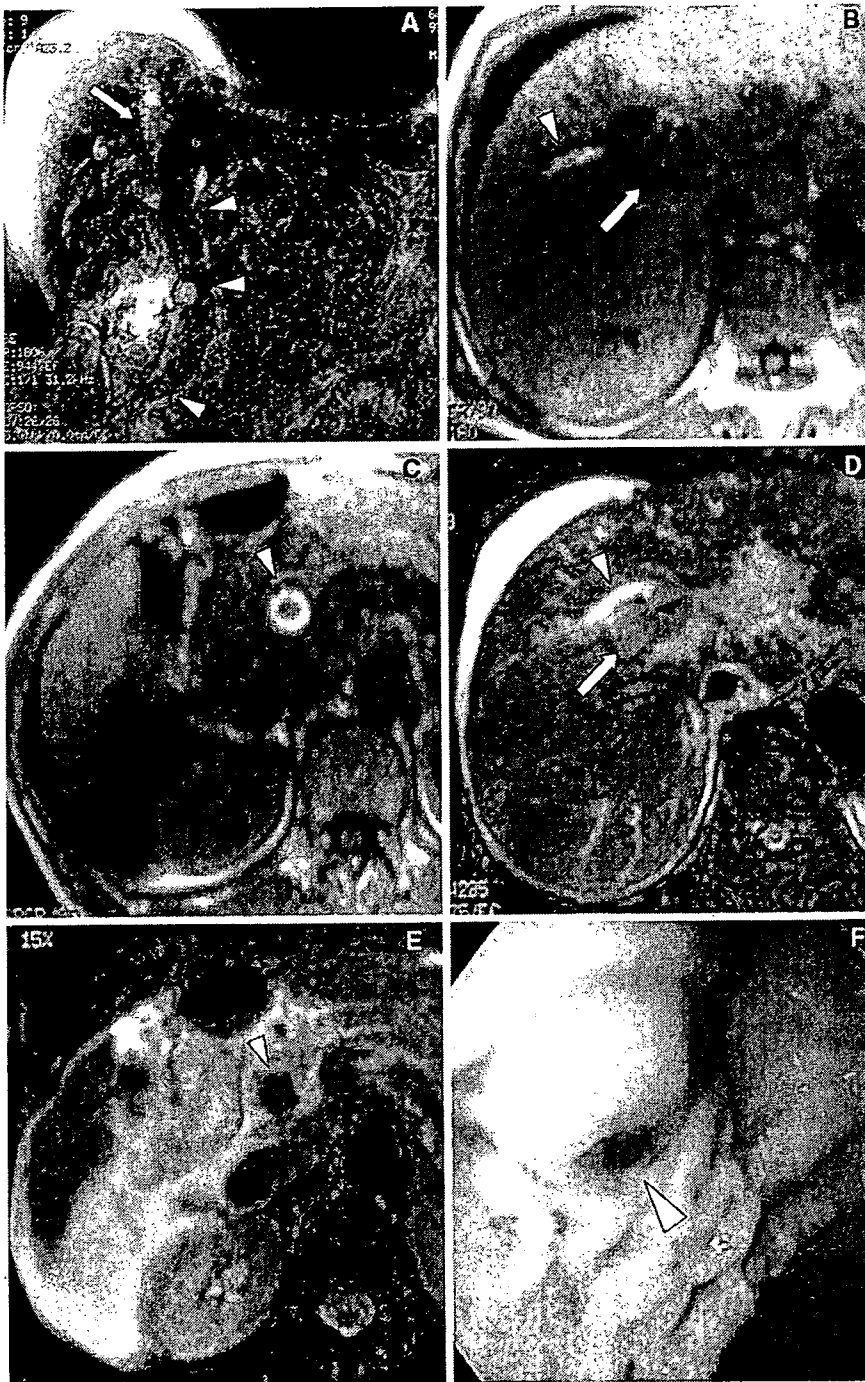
52-year-old man with HCC who presented jaundice. A MRCP shows filling defect of the left hepatic and common hepatic duct (arrowhead) and intrahepatic bile duct dilatation. B Coronal T2-weighted MR image (single shot first spin echo) shows hyperintense tumor thrombus (arrowhead). C On axial T1-weighted MR image (gradient echo), tumor thrombus shows hypointensity (arrow). The dilated left intrahepatic bile duct shows hyperintensity indicating biliary hemorrhage (arrowhead). D Arterial dominant phase of dynamic MR image (gradient echo) shows marked enhancement of the tumor thrombus with segmental enhancement of the lateral segment of the liver due to invasion of the left portal vein by HCC (not shown).
